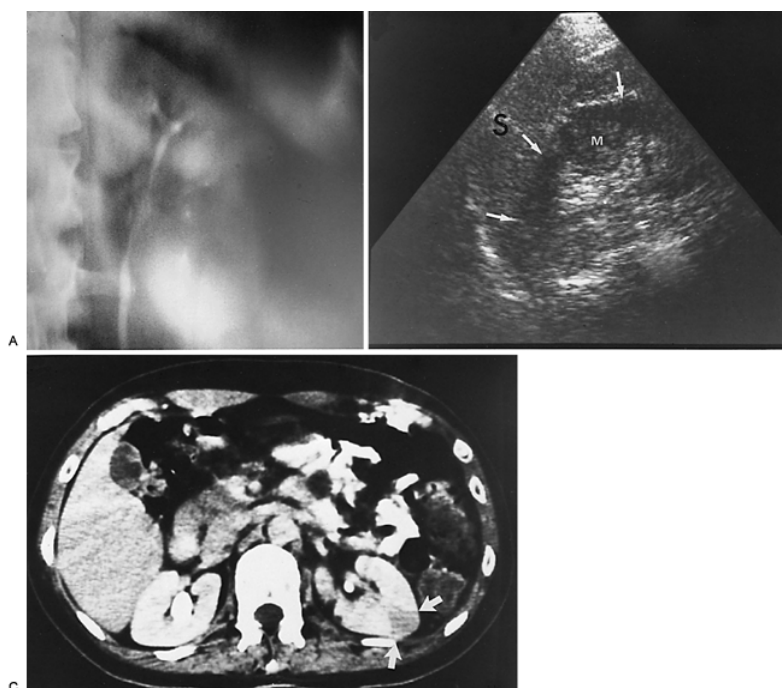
Acute focal bacterial nephritis. A: Excretory urogram. Five-minute tomogram demonstrates normally functioning upper and lower poles and a poorly margined midrenal mass with poor function and absent collecting system visualization. B: Ultrasound; longitudinal view of the left kidney demonstrates spleen (S) and left kidney (arrows). Note irregular midpole mass (M) of slightly higher echo texture than surrounding normal renal parenchyma. C: Contrast-enhanced computed tomography scan demonstrates a wedge-shaped area of low density (arrows) in the middle portion of the left kidney. The findings resolved after antibiotic therapy.
